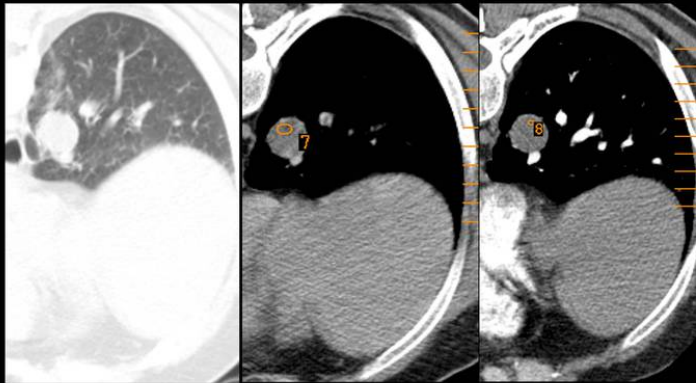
Smoker patient that was referred for CT guided lung biopsy. Axial CT images (note the patient is in prone position) show a sharply margined round nodular opacity in the right lower lobe (a). The nodule has fluid attenuation (b) and there is no enhancement after contrast administration (c).
